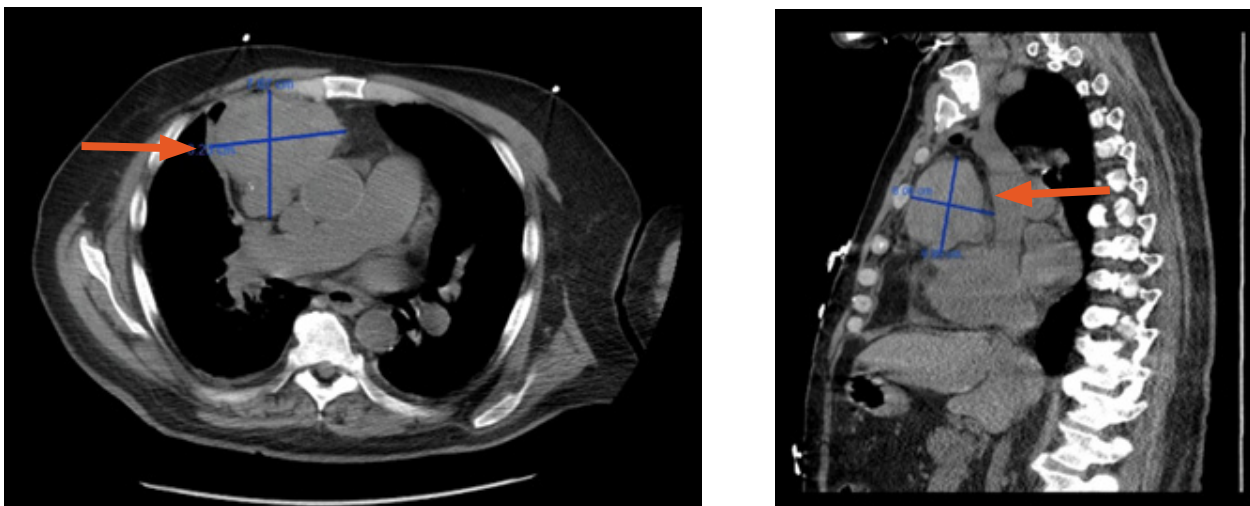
A secondary chest CT scan without contrast shows a large anterior mediastinal mass, approximately 8.2 cm x 7.7 cm in greatest axial dimension, consistent with a neoplastic process (orange arrows).
